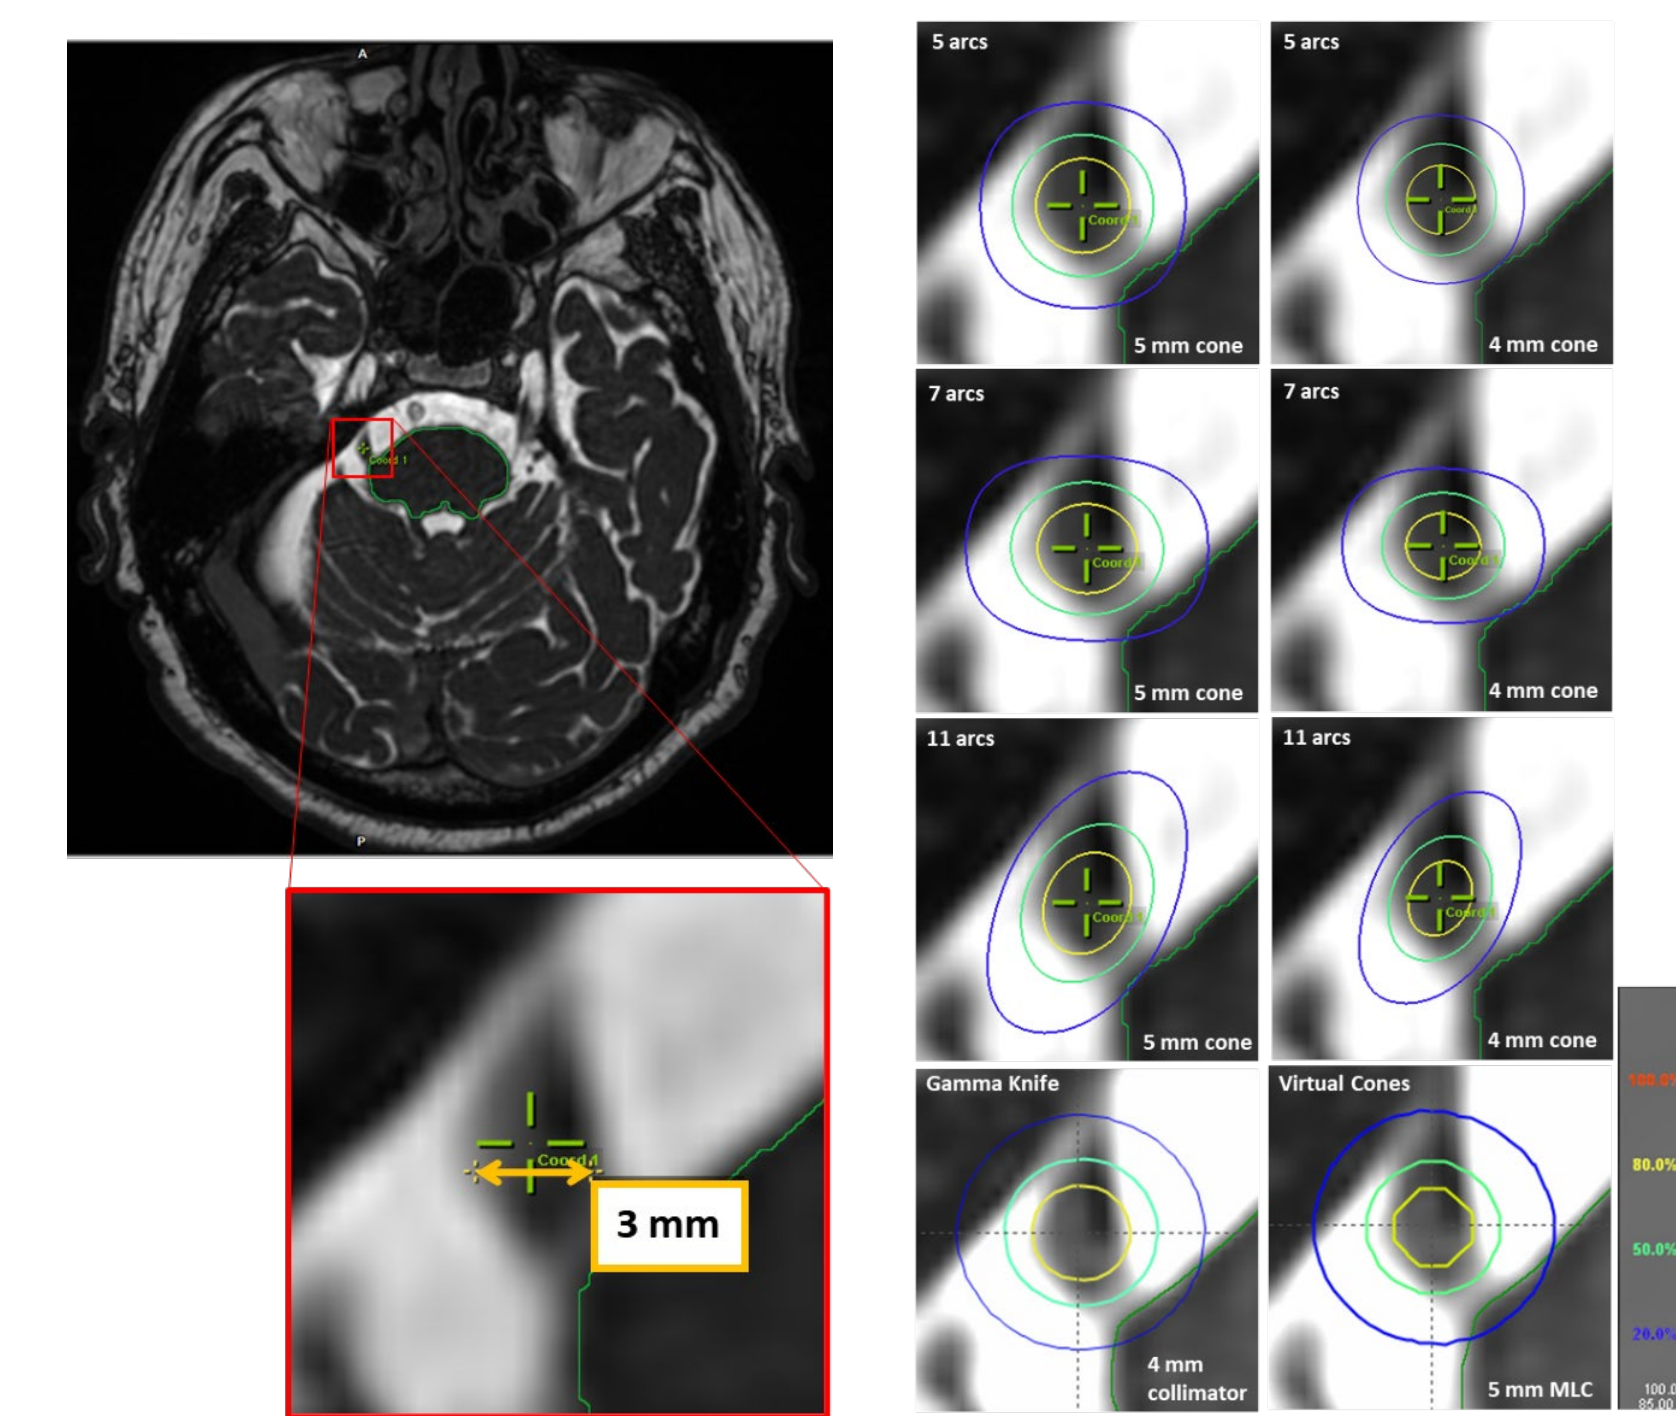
Cross-section dose distributions (Figure 2b) across the trigeminal nerve with each of the eight planning techniques, visualizing the same slice of the singular MRI dataset (amplified in Figure 2a).
